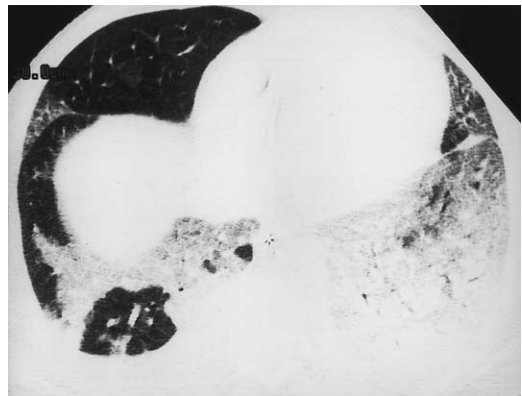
A 68-year-old man who has pulmonary edema and DAD. HRCT shows extensive left base and patchy right base consolidations with predominance of findings in the dependent regions of the lungs.
